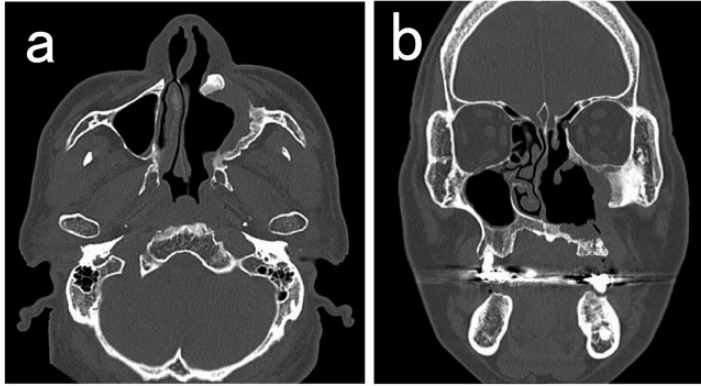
Computed tomography images 12 months after surgical resection showing that the lesion had been completely resected and that there was no apparent recurrence. (a) Axial view and (b) coronal view.
